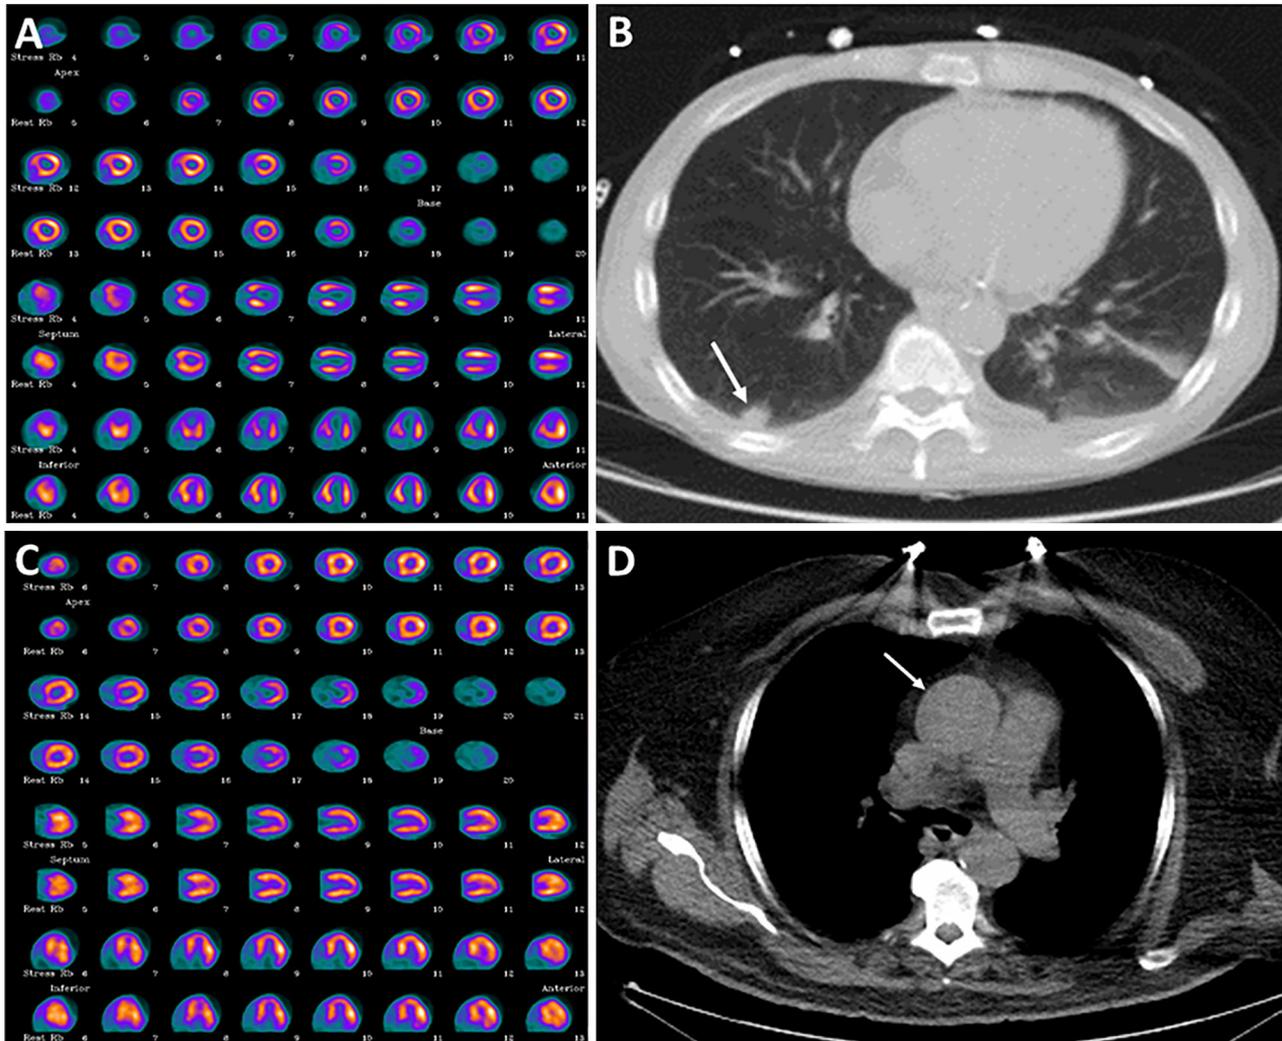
Examples of clinically actionable incidental findings on CTACs. A Rb-PET myocardial perfusion imaging in a 51-year-old male with hypertension, recent non-ST elevation myocardial infarction, and wall motion abnormalities on echocardiography showing mixed ischemia and scar involving the mid-apical anterior, mid-apical inferior, and apical lateral and septal walls. B CT performed for soft-tissue attenuation correction demonstrating a 1.3 cm right lower lobe lung nodule, biopsy of which showed squamous cell carcinoma. C Rb-82 PET MPI in a 77-year-old male with known coronary artery disease, diabetes mellitus, hypertension, obesity, hyperlipidemia, and atypical chest pain demonstrating a small, mild fixed inferoapical defect consistent with scar. D CT performed for soft-tissue attenuation correction demonstrating an ascending aortic aneurysm measuring 5.2 cm by 4.6 cm (arrow).
